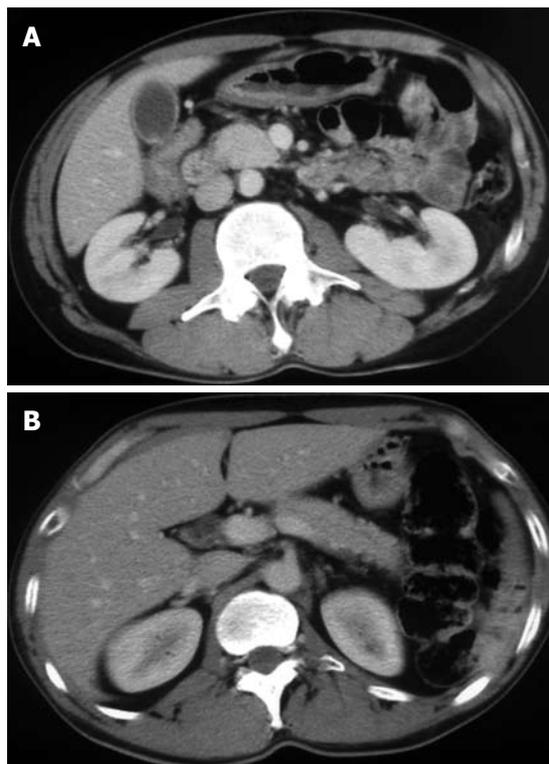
Abdominal enhanced CT scan with contrast medium in July 2007. As compared with CT imaging taken in May 2007, swelling of the pancreatic head had significantly regressed (A). Irregular dilatation of the main pancreatic duct had improved with the whole body bulk being reduced (B).
